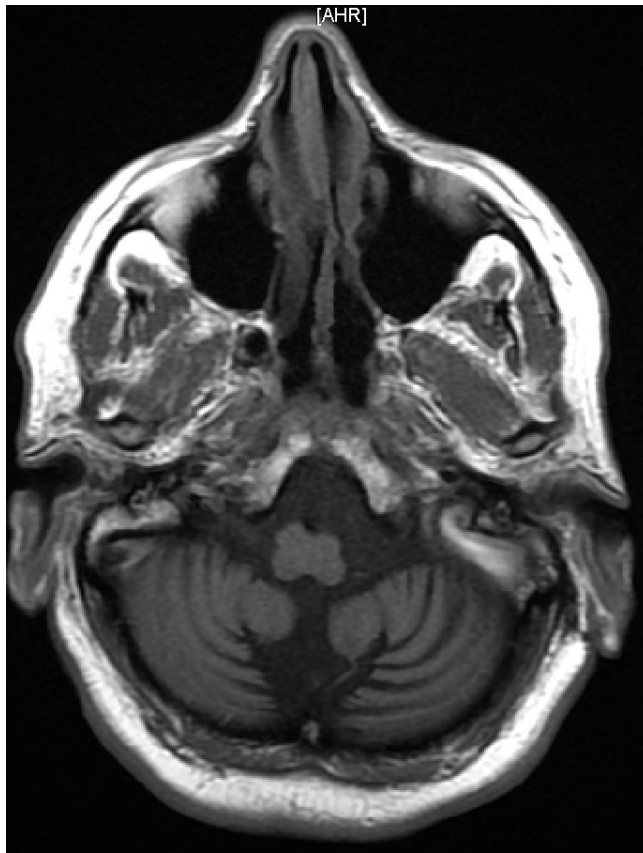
MRI scan, axial T1 sequence show diffuse cerebellar atrophy
